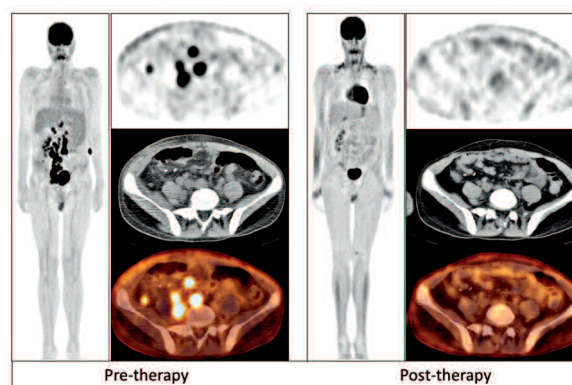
A 12 years old girl was diagnosed as post-transplant lymphoproliferative disorder post heart transplantation. The ^{18}F -FDG PET/CT of pre-therapy showed multiple foci of ^{18}F -FDG accumulation in the retroperitoneal region. The ^{18}F -FDG PET/CT of post-therapy did not show abnormal ^{18}F -FDG accumulation. Based on these ^{18}F -FDG PET/CT results, we classified the therapy response as improvement.
